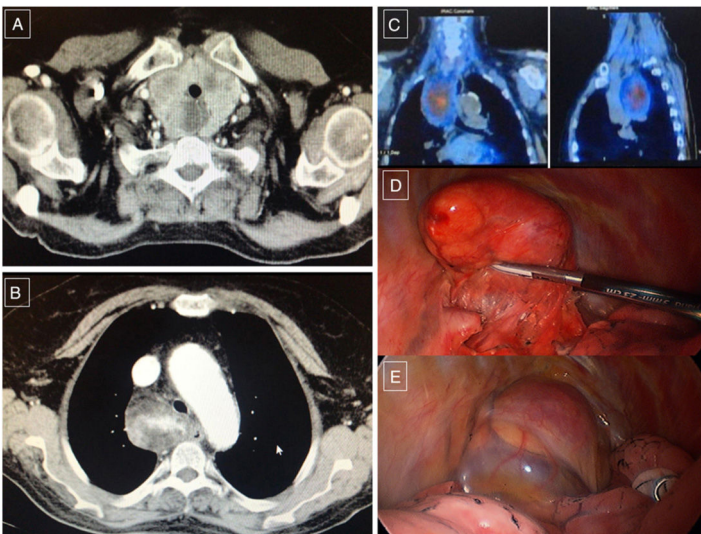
(A and B) CT scan showing mediastinal tumor. (C) SPECT showing tracer uptake in the mediastinal lesion. (D and E) Intraoperative findings of the thoracoscopic dissection of the mass.
